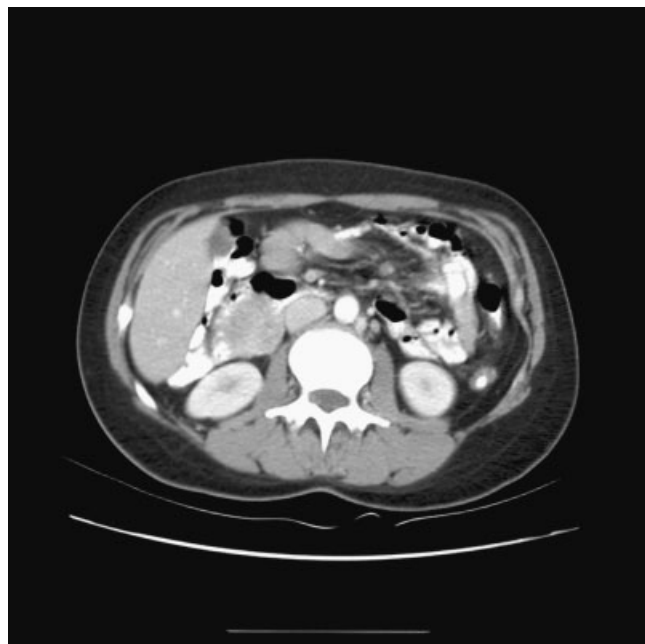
Computed Tomography (CT) image of the GIST arising from the posterior wall of the second part of the duodenum with very well-circumscribed borders.
